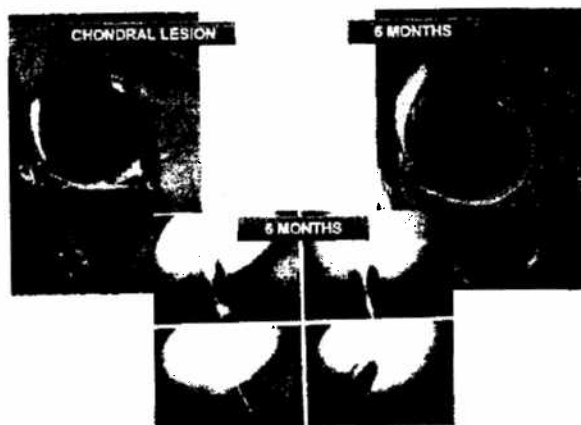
MRI and 6-month "second-look" arthroscopic appearance of MACI implant.
